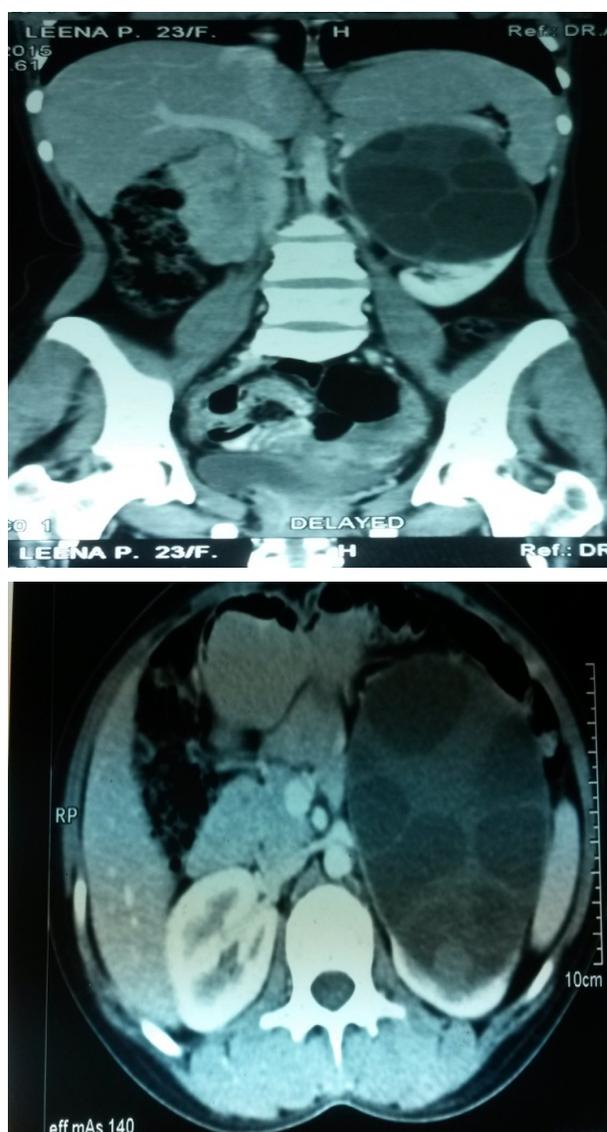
CT N MRI Image enlarged lesion on left side kidney.
